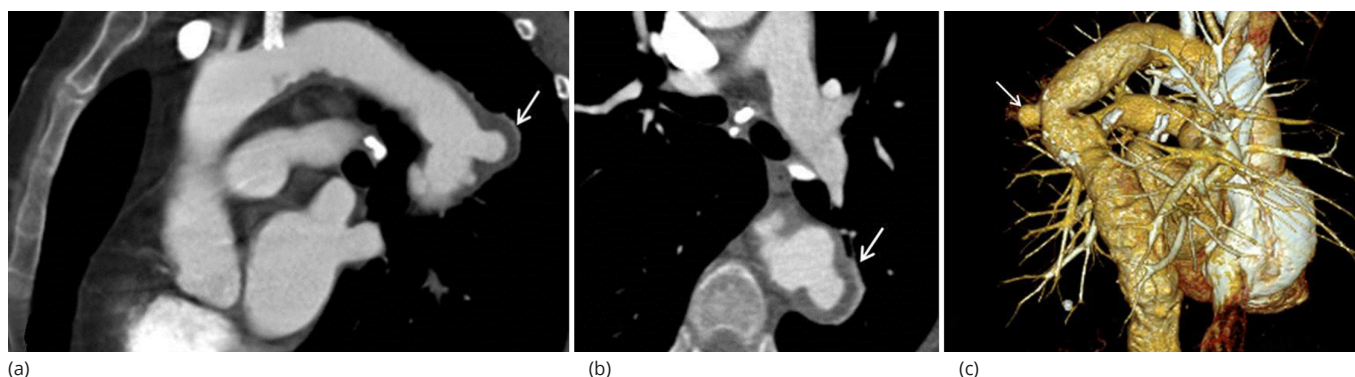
a. Computed tomography angiogram (CTA) in the sagittal plane demonstrating a 2.0 × 2.5 cm penetrating aortic ulcer (arrow) on the lateral proximal descending thoracic aorta. b. CTA in the transverse axial plane demonstrating the penetrating aortic ulcer (arrow) on the lateral proximal descending thoracic aorta. c. CTA with 3-D processing demonstrating a penetrating aortic ulcer (arrow) off the proximal lateral descending thoracic aorta. There are diffuse luminal irregularities consistent with atherosclerosis.
